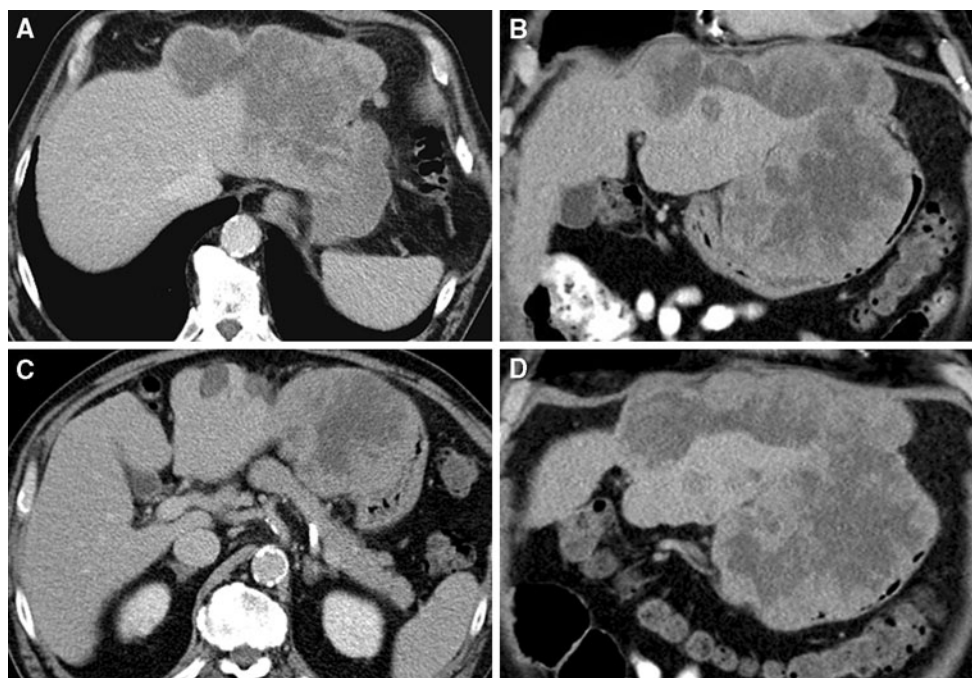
(A and C) Axial and (B and D) coronal CT scan of the *upper* abdomen (portal–venous phase) showing a large tumour mass in the *left* liver lobe with partial central necrosis bulging the small curvature of the stomach
